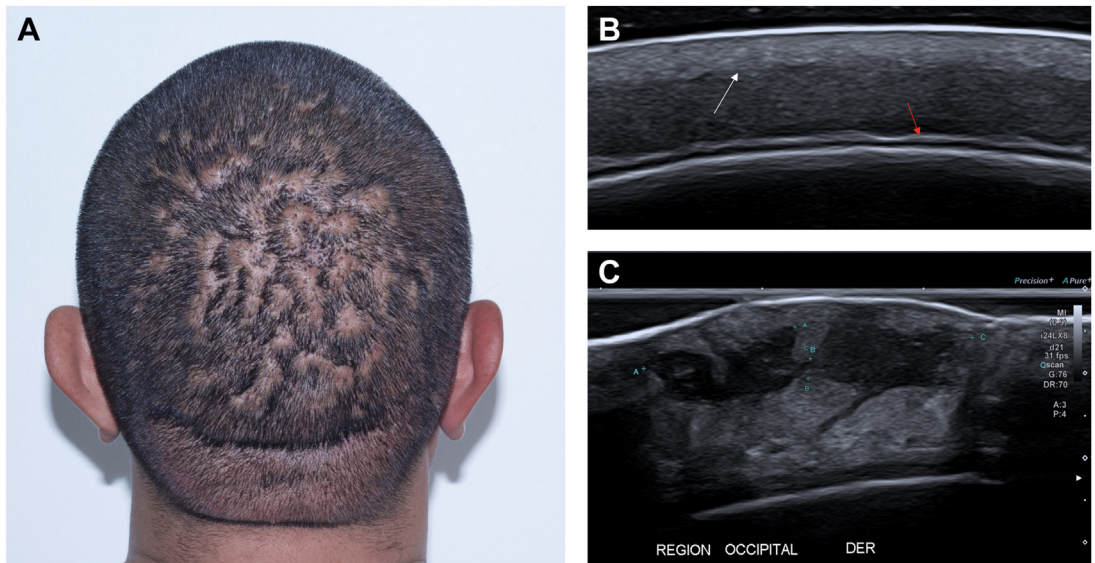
DCS clinical presentation (A). (B) A healthy scalp ultrasound with typical thickness and echogenicity. The white arrow shows the hypodermal interface; the red arrow indicates epicranial aponeurosis. DCS ultrasound shows thickening of the dermis and subcutaneous planes, with loss of definition of the dermo-hypodermal interface, increased echogenicity of subcutaneous adipose tissue, and presence of confluent cystic lesions with the appearance of merging pseudocysts (C). Courtesy of C Whittle, MD, Santiago, Chile.
